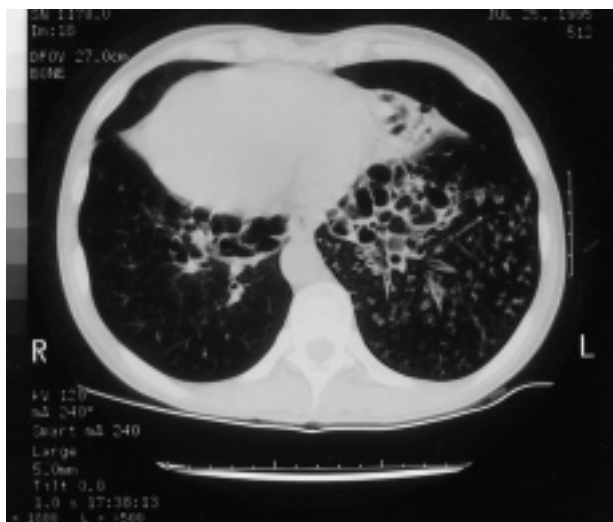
Chest computed tomography (CT) scan of patient 8 showing dextrocardia, bronchiectasis and diffuse centrilobular small nodules throughout both lungs.
